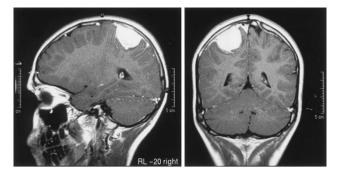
MRI (T1 weighted, after Gadolinum injection): a right parietal, parasagittal mass, strongly and diffusely enhancing after Gadolinum injection (Case 2). Dural "tails" are present, suggesting the preoperative diagnosis of meningioma.
